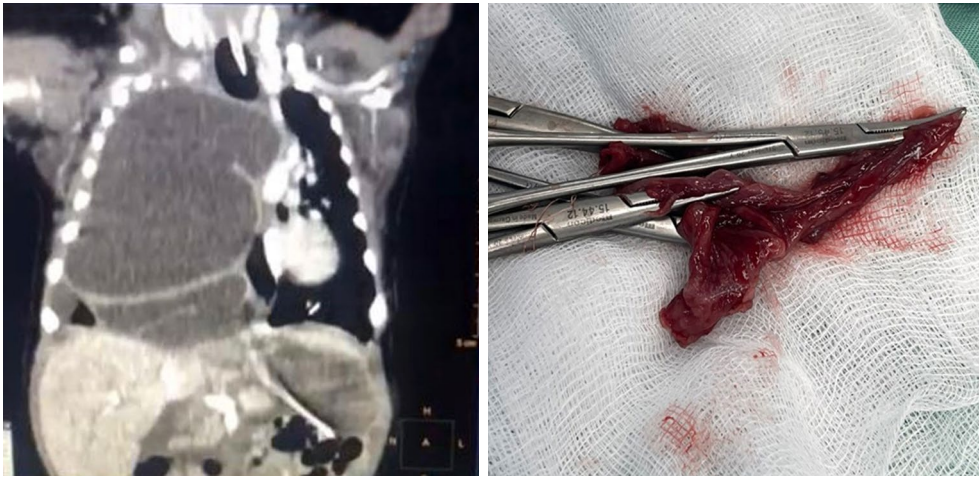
Computed tomography demonstrates the integrity of the diaphragm and a cyst septate image 132×59×41 mm in size and 120 mL in volume, located extrapleurally near the right paravertebral. Intraoperative image of the esophageal duplication cyst; the cyst had a layer of muscle and was connected with an obliterated fistula to the esophagus.
